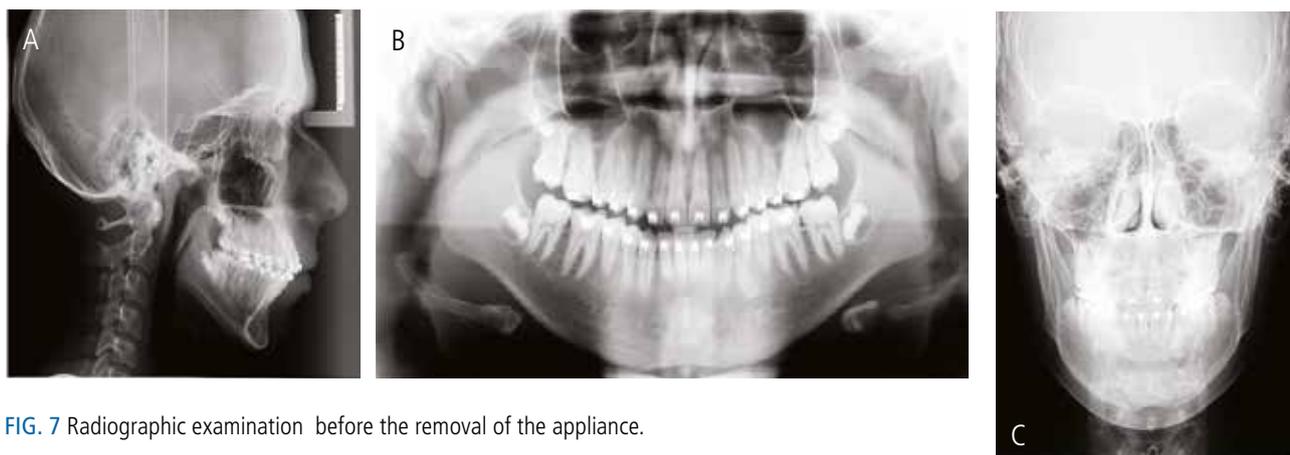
Radiographic examination before the removal of the appliance.
